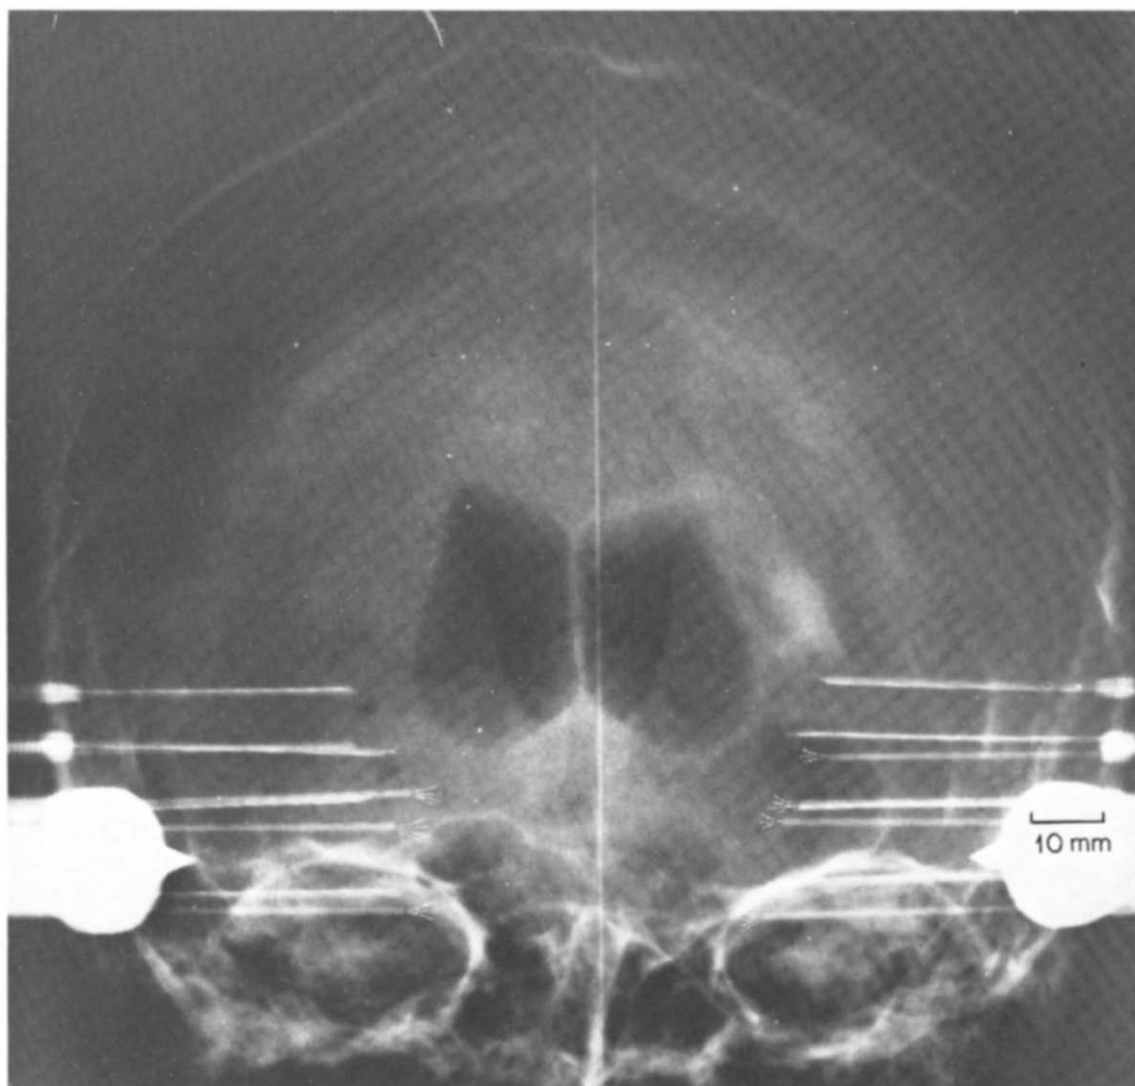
A-P X-ray showing the locations of "sprays" of seven fine wires bilaterally placed, from top to bottom, in Ammon's horn (not seen in patient's right side), hippocampal gyrus, and approximately 3 cm anterior in amygdala and uncus. The fine wires, clearly visible in the negative, have been retouched for photographic reproduction.
